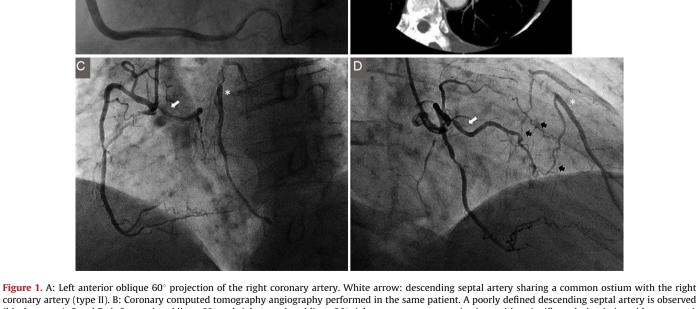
A: Left anterior oblique 60° projection of the right coronary artery. White arrow: descending septal artery sharing a common ostium with the right coronary artery (type II). B: Coronary computed tomography angiography performed in the same patient. A poorly defined descending septal artery is observed (black arrows). C and D: Left anterior oblique 60° and right anterior oblique 30° right coronary artery projections with a significant lesion in its mid-segment. A descending septal artery originating from the proximal segment (type I, white arrows) provides collaterals to a chronically occluded left anterior descending (asterisk) through several septal branches (black arrows).
